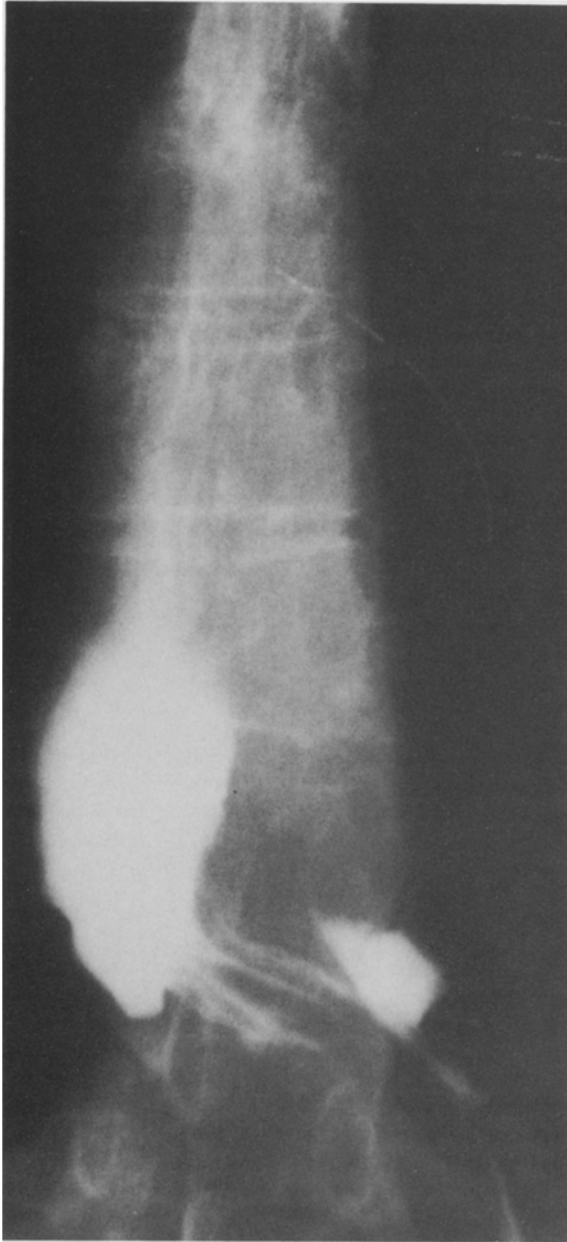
Radiographic demonstration of a perforation from pneumatic dilation. This postdilation esophagram demonstrates extravasation of contrast from the distal esophagus into the mediastinum.
